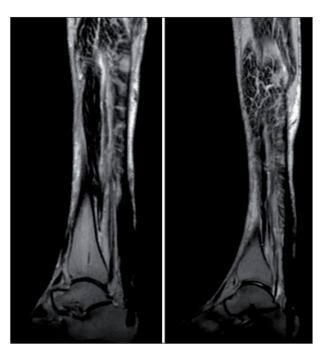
Two sagittal postoperative MRI view showing LARS integration in the calcaneus tunnel and fatty degeneration of calf muscles
